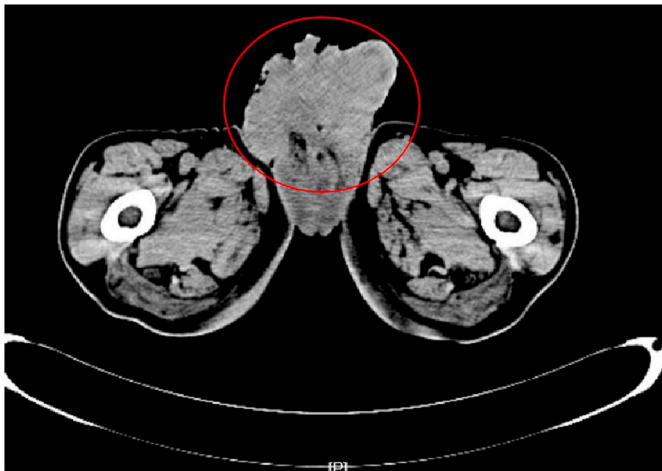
Preoperative CT showing the deep ulcerating lesion occupying the entire exterior genitalia with unclear corpus cavernosum of penis and corpus spongiosum.
